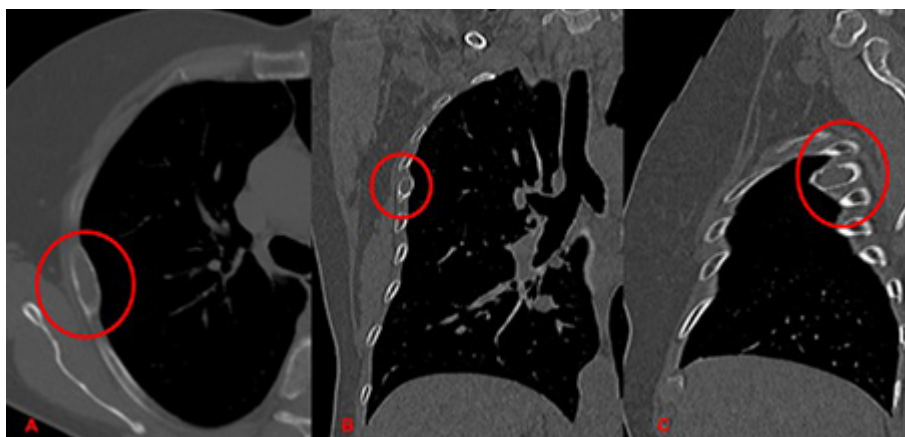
Computed tomography showing a lytic lesion in the midsection of the fifth right costal arch. A. Axial view. B. Coronal view. C. Sagittal view.
